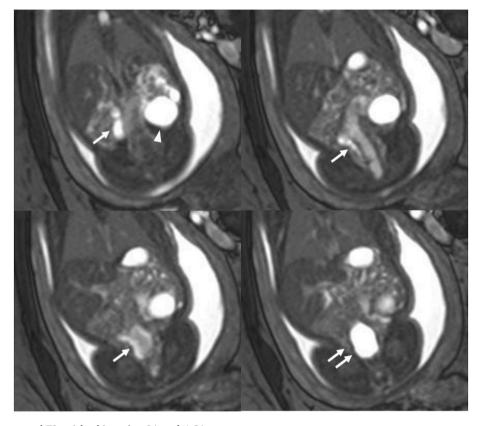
MRI findings (fat-saturated T2 weighted image) at 24 weeks' GA. Single and double arrows showing right ureteropelvic dilatation with urine storage in bladder. Arrowhead showing left kidney with a 1.5-cm cystic mass and multiple small cysts.
